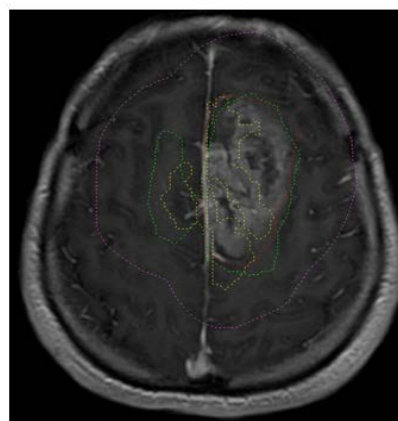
Volume comparison on pre-treatment gadolinium-enhanced T1-weighted for patient 1. A large part of GTV' (green) and Vperf (yellow) are included in GTV (red) in the left hemisphere. In the right hemisphere, the hyper-perfused area is predictive of tumour recurrence. GTV' is completely included in PTV (pink).
